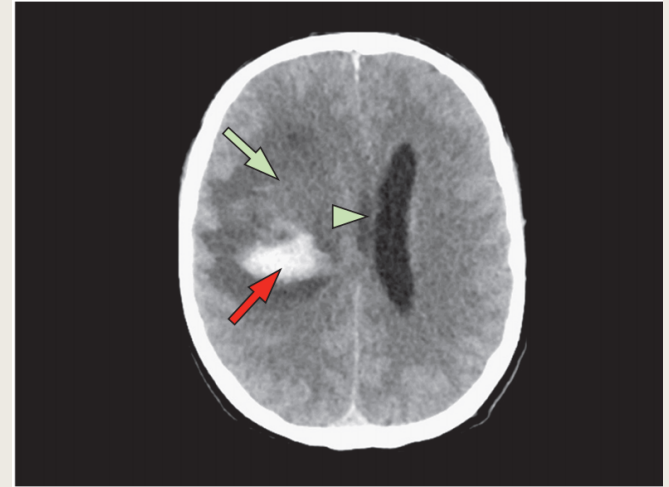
Non-contrast CT scan, axial slice, 8 days after intracerebral haemorrhage.
